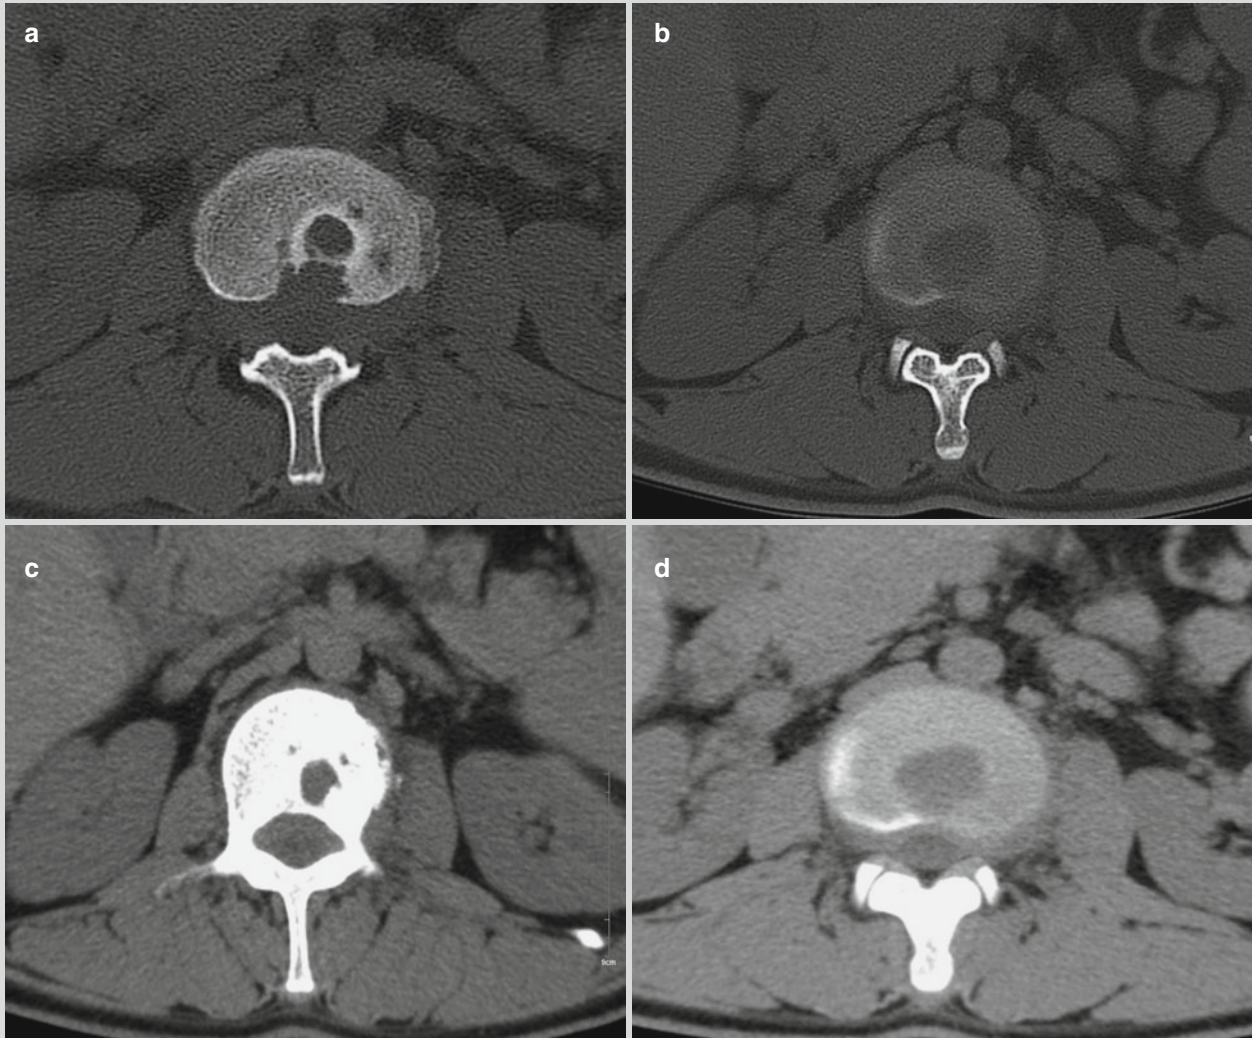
Brucellar spondylitis. (a, b) Plain lumbar CT scanning demonstrates multiple bone destructions at the vertebra by bone window, with proliferation and sclerosis at the vertebral margin. The intervertebral disk is demonstrated with inner low-density
